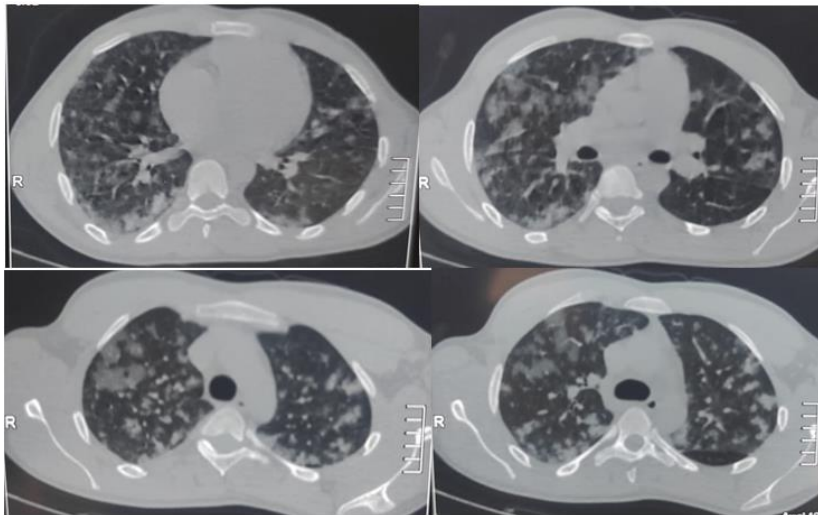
Computed Tomography Angiographic images reconstructed in the axial plane
